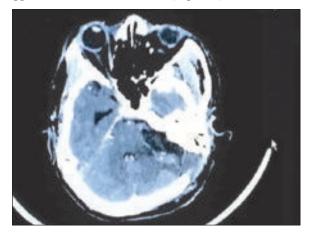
MRI of the brain after excision of the mass.
